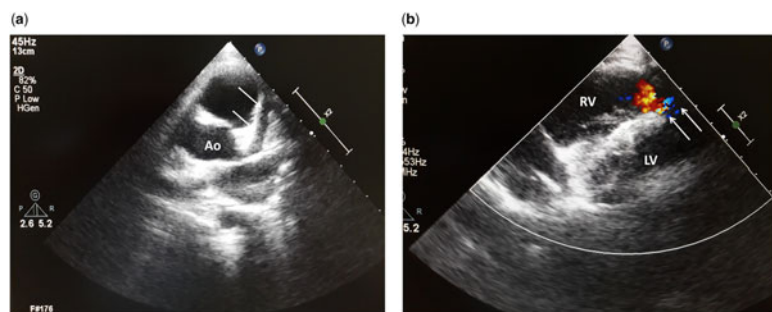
(a) Transthoracic short-axis view of two-dimensional transthoracic echocardiography shows a dilated left main coronary artery (white arrows, Ao = aorta). (b) Right ventricular view of echocardiogram shows a right ventricle of normal size and colour Doppler shows forward flow into the apical region of right ventricle (white arrows, RV = right ventricle; LV = left ventricle).
